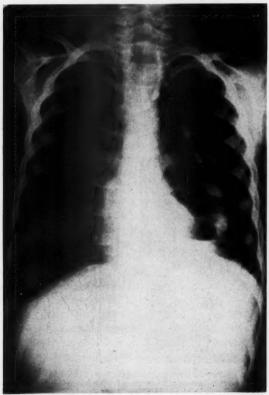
Postoperative roentgenogram of case I taken two years after operation. No evidence of obstruction. Clavicle appears to have regenerated.
